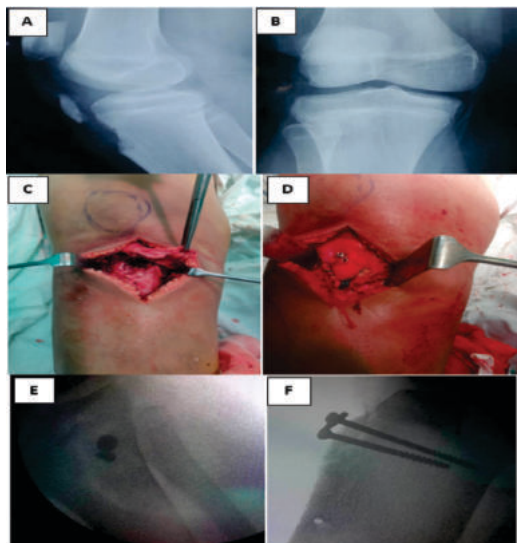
Pre operative radiographs (A and B), intra operative
